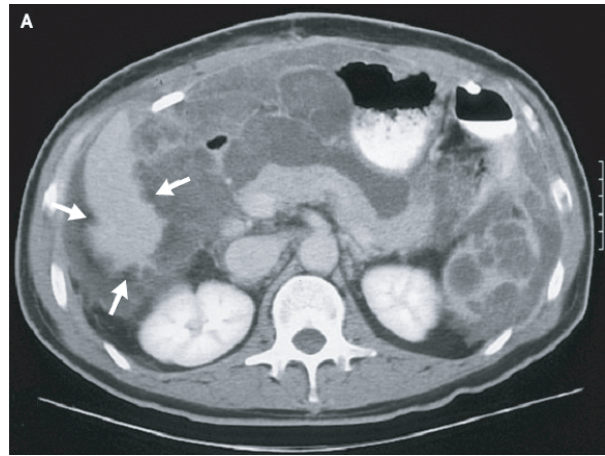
CT scan of the abdomen in PMP
